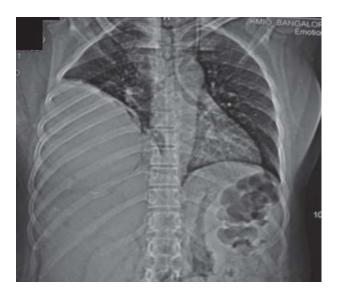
Chest radiograph (postero-anterior view) showing a mass in the right hemithorax.
